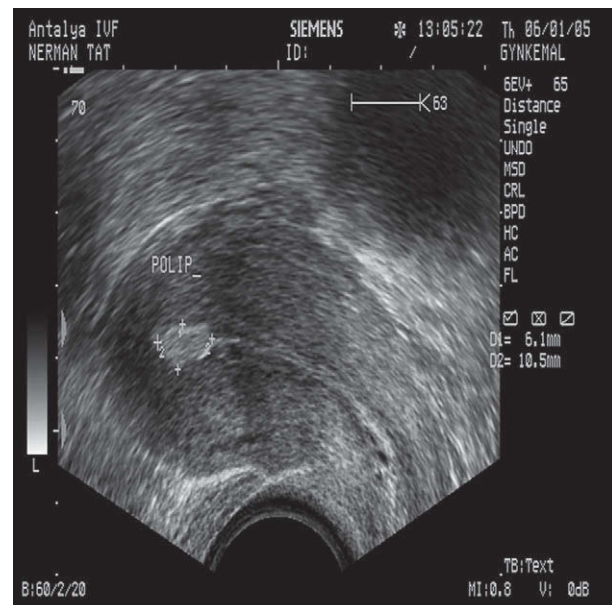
Appearance of endometrial polyp on transvaginal ultrasound.
